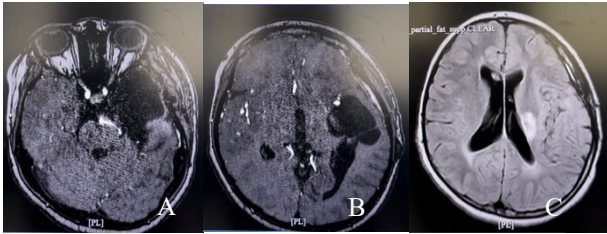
The MRI of the head performed without intravenous contrast revealed the presence of an arachnoid cyst located in the left temporal region, which is clearly visible on the axial T1-weighted images (A, B). Additionally, there is evidence of a parenchymal defect in the left temporal lobe accompanied by peritumoral gliosis, as demonstrated on the T2-weighted fluid-attenuated inversion recovery (FLAIR) sequences (C)
